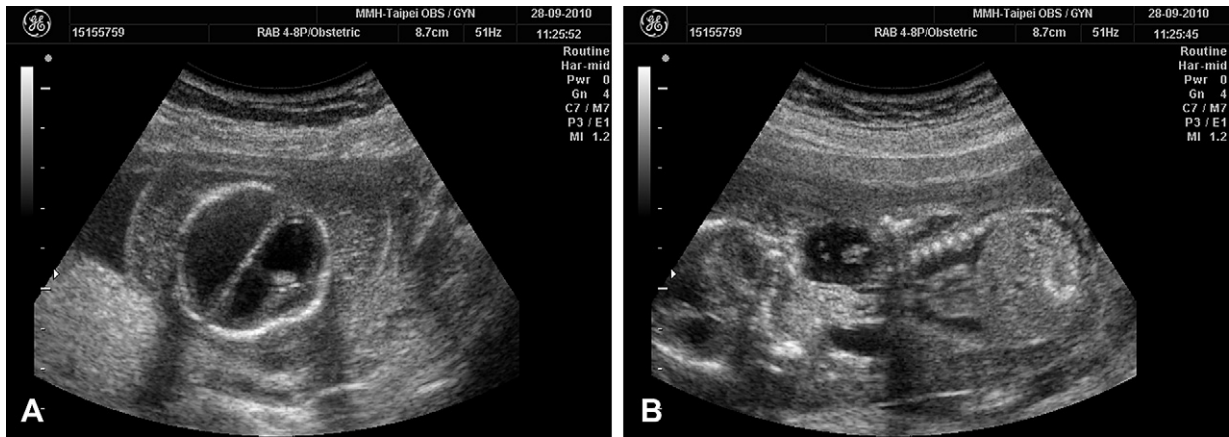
Prenatal ultrasound of Case 4 at 17 gestational weeks shows (A) bilateral ventriculomegaly and (B) nuchal cystic hygroma.
